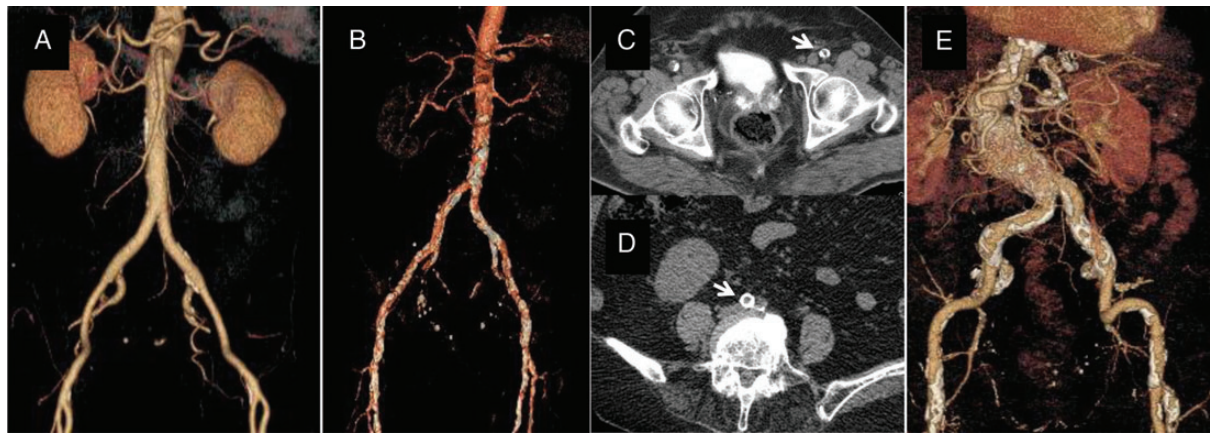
Multi-detector row computed tomography for assessment of the peripheral vasculature to decide on optimal access sites for transcatheter aortic valve implantation. Aortogram of ‘ideal’ arterial anatomy for a TF procedure: non-calcified iliac and femoral arteries which are of good calibre and not too tortuous (A). Multi-detector computed tomographic aortogram showing heavy arterial calcifications in the aorta and iliac arteries (B), non-concentric but significant calcification in the iliac artery (C, arrow), and concentric calcification in the aorta (D, arrow). Multi-detector row computed tomography aortogram showing both heavy calcification and excessive tortuosity of iliac arteries (E).
